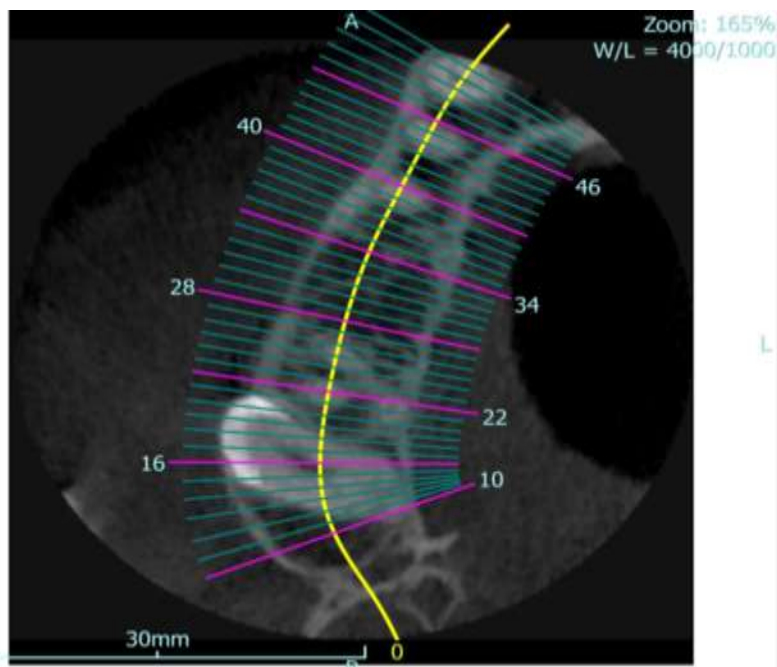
The CT image in an axial plane
